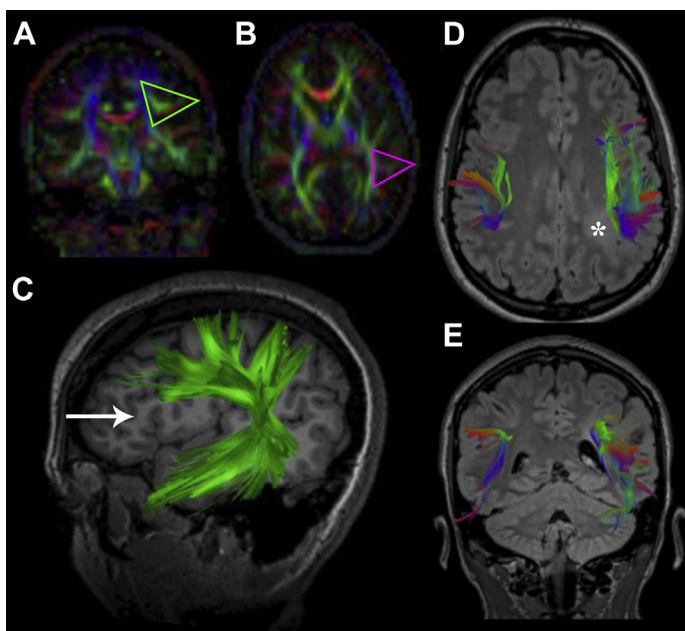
(A, B) Coronal and axial direction-encoded color FA maps show the typical locations for seed placement for generating the left AF in a volunteer: periventricular *green triangle* and genu *purple triangle*. (C) Sagittal 3D-T1 image shows only streamlines included in both seed points. Note the lack of frontal fibers to the Broca area (*arrow*). (D, E) Axial and coronal 3D-FLAIR images with fused bilateral AF tracts show expected asymmetry in a right-handed (Edinburgh Handedness +100) individual with an infiltrative left parietal lesion (*asterisk*).
